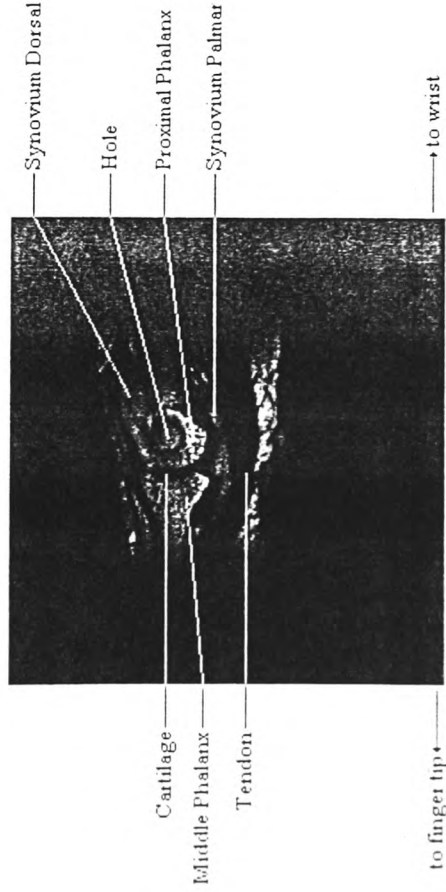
MRI scan of an RA patient.
